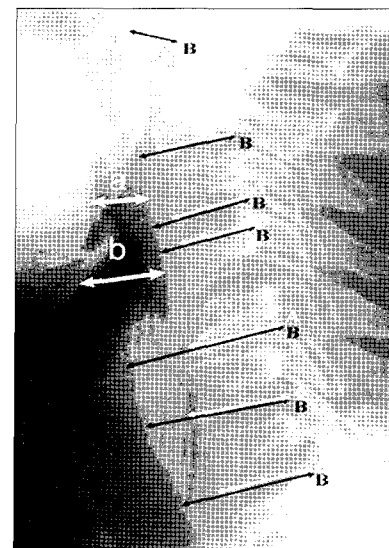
The method of measurement of width of the airway caliber and prevertebral soft tissue swelling by use of the cervical lateral X-ray film. Airway caliber is measured at the level of above and below epiglottis (a and b). Prevertebral soft tissue is measured as ratio of vertebral body's AP diameter and distances from anterior margin of prevertebral soft tissue to posterior margin of vertebral body (B/A).
